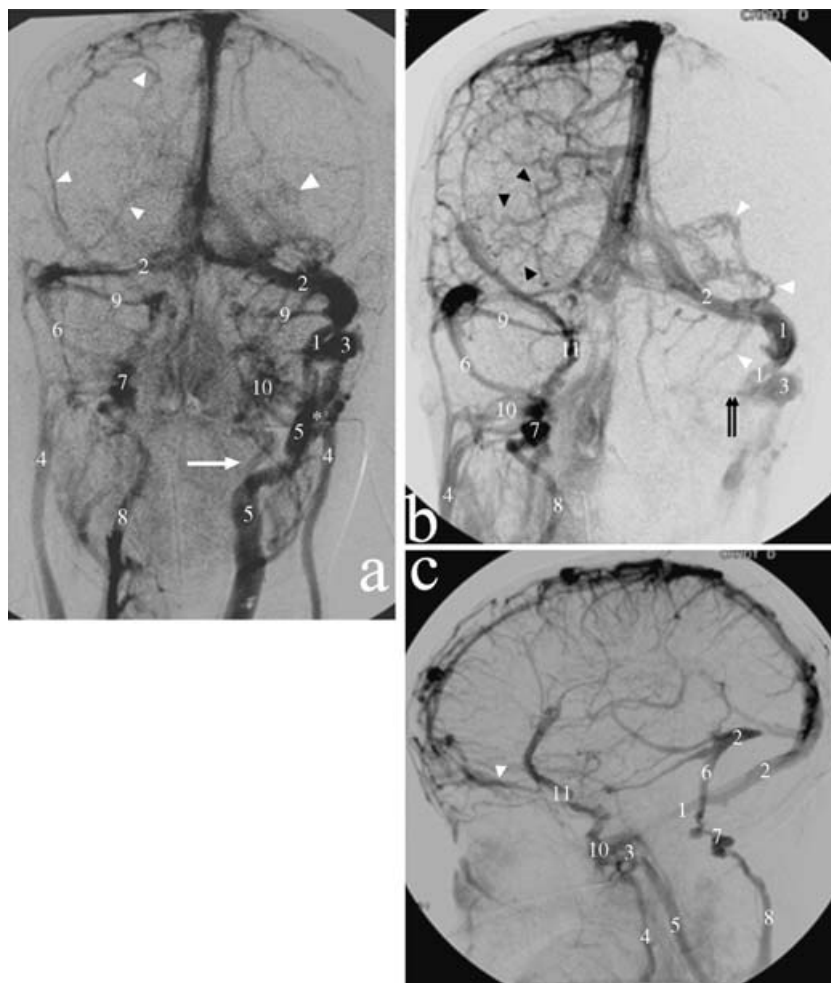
Case 2. DSA (BN3000, Philips, Best, The Netherlands). Aside from confirming the CTA findings, DSA disclosed signs of venous hypertension, partial obstruction of the superior sagittal sinus draining cortical veins from the left convexity (not shown), and compensatory collateral drainage through an enlarged system of diploic veins on both sides. (a) Late venous phase obtained after injection of contrast agent into the ascending aorta, anteroposterior view. Details as in previous figures. The absence of the left sigmoid sinus is confirmed. The right transverse sinus is hypoplastic compared to the left and drains into a sigmoid sinus (6). Drainage of the right sigmoid sinus occurs through a posterior condylar emissary vein (7) into a deep cervical vein (8). Note the absence of a right IJV. The left pterygoid plexus (10) is prominent and drains into a large deep facial vein, which ultimately becomes a common facial vein (white arrow). Cortical veins have washed out at this stage and only a few prominent diploic veins are recognized (white arrowheads) on both sides, compatible with collateral venous flow. (b) Early venous phase after right ICA injection, anteroposterior view. There is simultaneous opacification of the transverse sinuses. Controlateral drainage into the PSS is conspicuous. The anterior-medial connection of the PSS with the middle meningeal veins (not seen here) is faintly opacified (double black arrow). A right laterocavernous sinus (11) (San Millán Ruíz et al. 1999; Gailloud et al. 2000) receives a prominent superficial middle cerebral vein and drains into a voluminous pterygoid plexus (10). This drainage pattern was also seen on the left side (not shown). The cortical veins (black arrowheads) on the right display a 'corkscrew' appearance suggesting a certain degree of venous hypertension. Note that prominent diploic veins have already appeared on the left (white arrowheads). (c) Lateral view, right ICA injection, slightly earlier venous phase than (b) confirming the absence of left sigmoid sinus. The prominent left diploic veins seen in (b) are within the frontal bone and drain into the supraorbital veins by way of a large orbital diploic vein (arrowhead). The cavernous sinuses were never observed, but there were no signs in favour of a cavernous sinus thrombosis in any of the imaging modalities used during the investigation. No inferior petrosal sinuses were demonstrated on either side.
